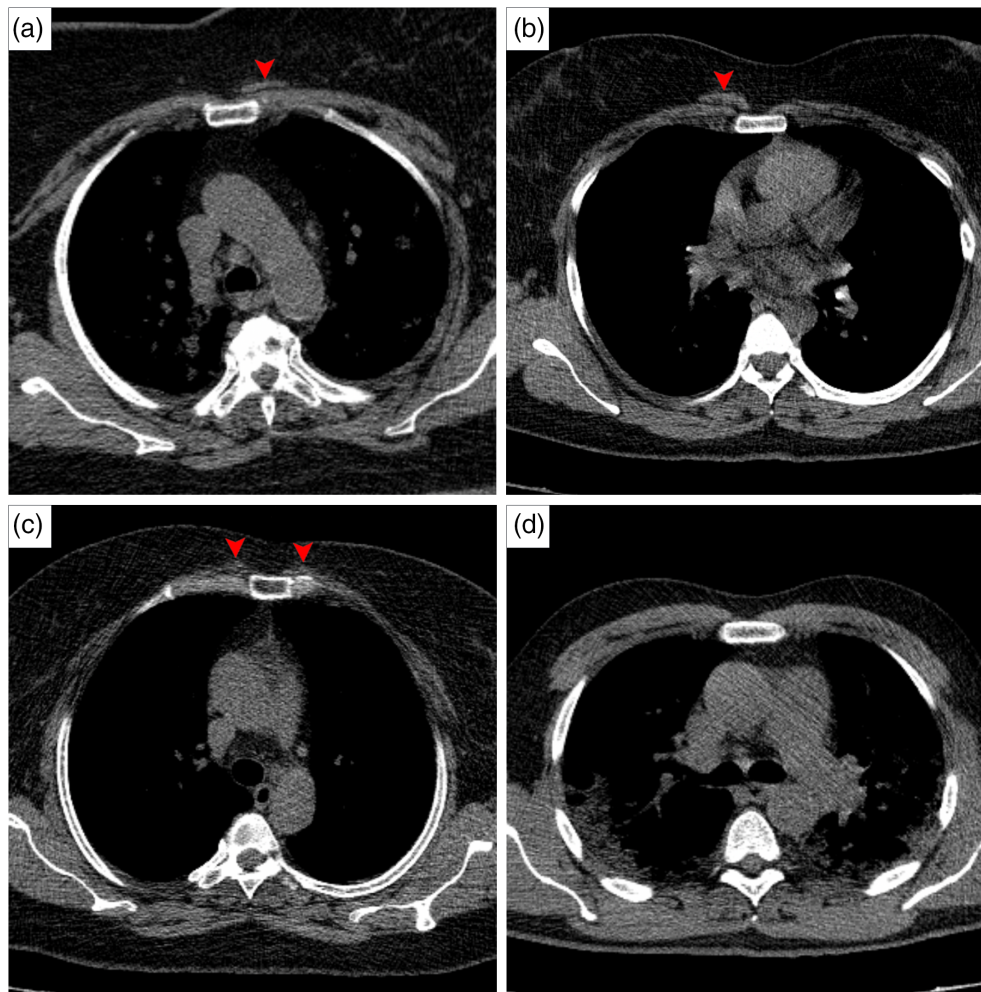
Axial CT images showing left side sternalis muscle (a), right-sided sternalis muscle (B), bilateral sternalis muscle (C), and the absence of sternalis muscle (D). Bellies of the sternalis muscle are indicated by red arrowheads
